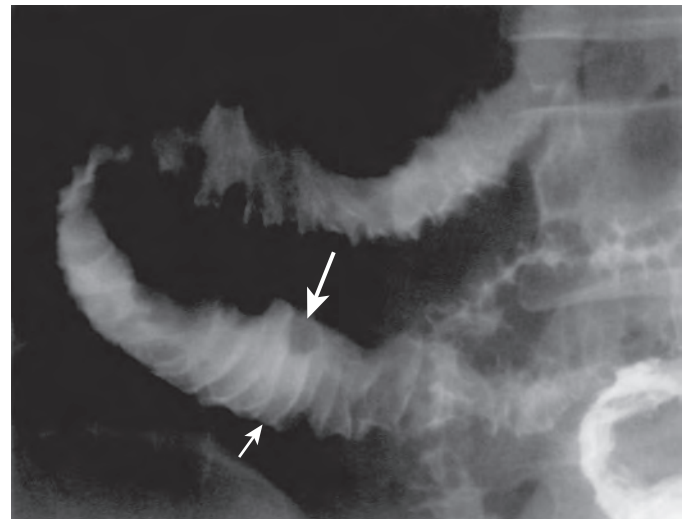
Amyloidosis involving the small bowel. This spot radiograph from a small bowel follow-through shows smooth, thickened folds (small arrow) caused by edema from low-grade ischemia and focal nodularity (large arrow) caused by amyloid deposits in the submucosa.
